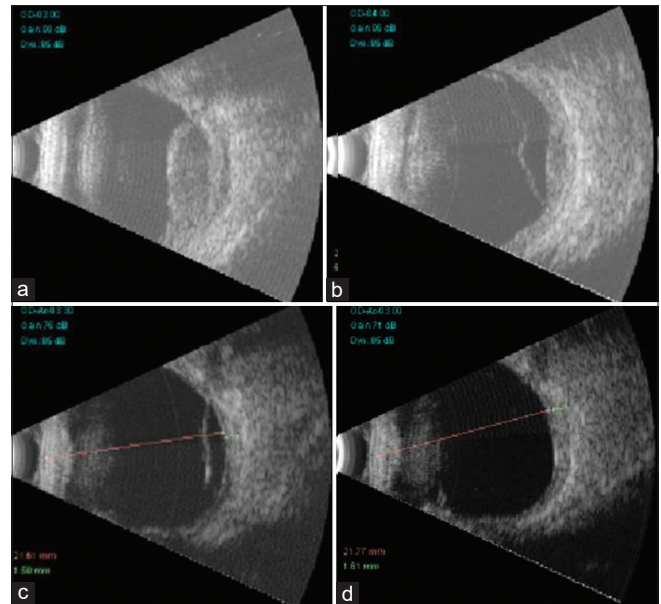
B-scan ultrasound showing (a) a dome-shaped mass with homogeneous dense echogenicity with inferior retinal detachment and T-sign but no choroidal excavation at presentation; (b and c) reducing height of the mass and fluid collection in the sub-Tenon space after 1 week and 3 weeks of the treatment; and (d) the mass and sub-Tenon fluid have resolved after 2 months of the treatment
